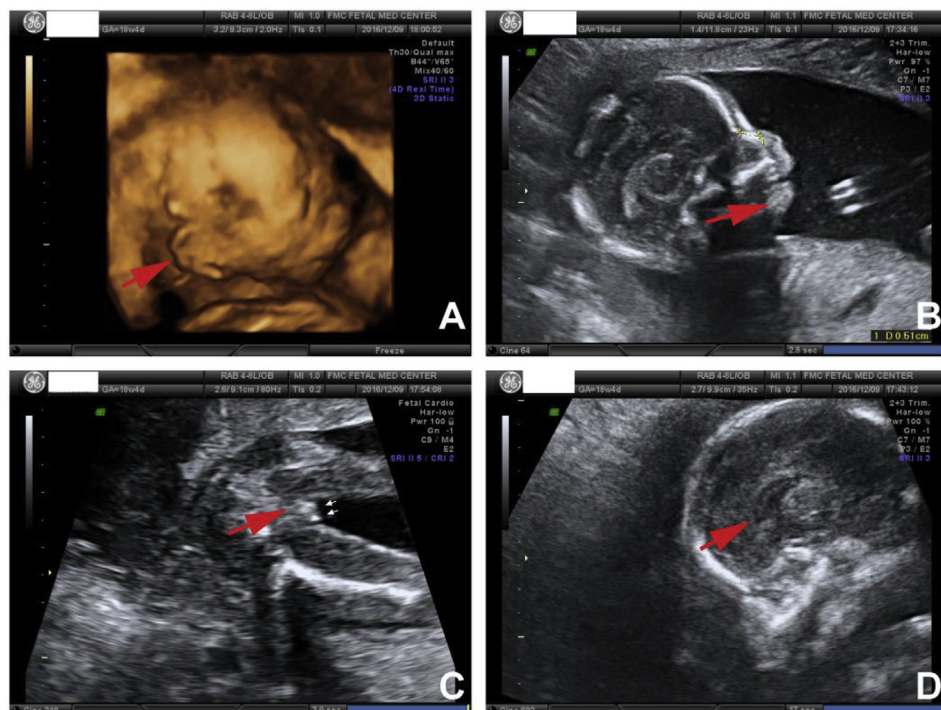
The arrow denotes the site of fetal ultrasound showing bilateral low-set ears (A), micrognathia (B), clitoromegaly (C), and partial depletion of the corpus callosum (D).
